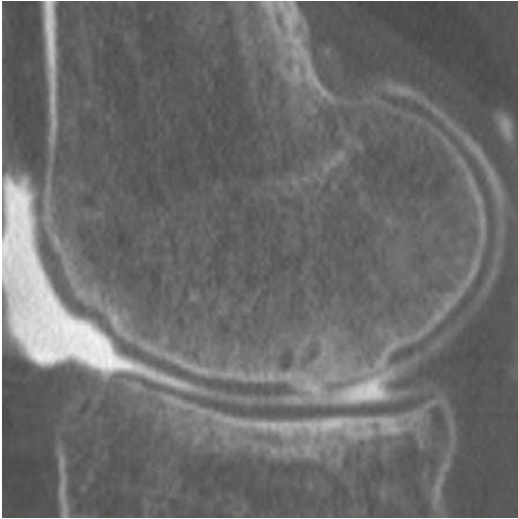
Computed tomography (CT) arthrogram (*sagittal cut*) of the medial femoral condyle after failed microfracture showing a large intralesional osteophyte covered with only a thin fibrous layer
